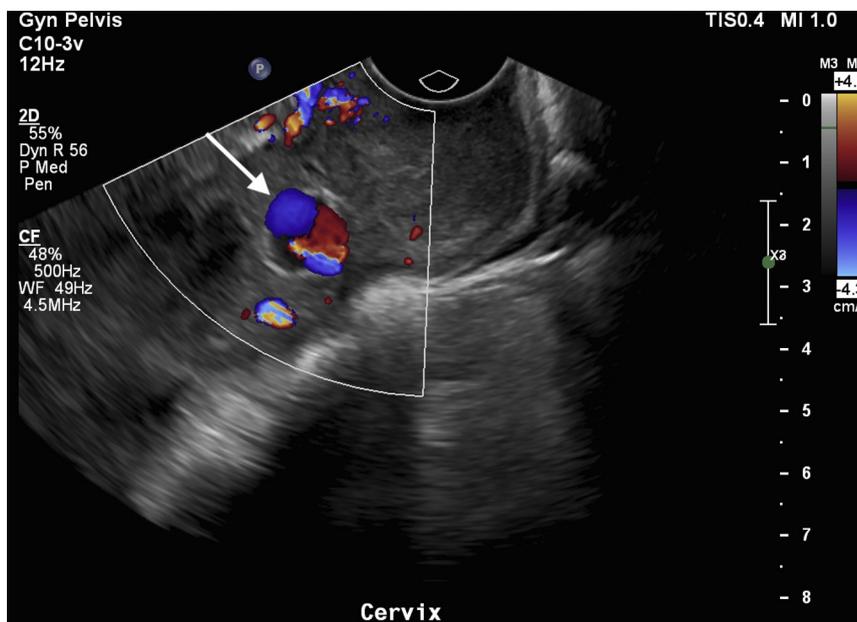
Transvaginal ultrasound with arrow denoting the pulsatile mass in the cervix with “yin-yang” flow on Doppler, suggestive of a uterine artery pseudoaneurysm.
